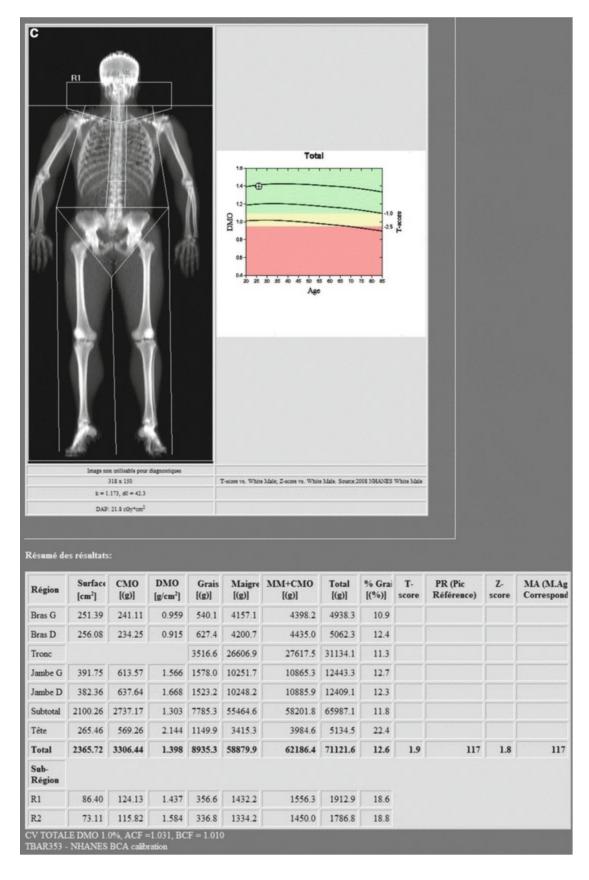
Cervical sprain between the spinous processes of the first and second thoracic vertebrae. Sagittal (a) and axial (b) STIR MRI shows interspinous ligament tear and edema seen as a hyperintensity signal. Detailed DXA measurements with cervical sub-region R1 and R2 (c)
